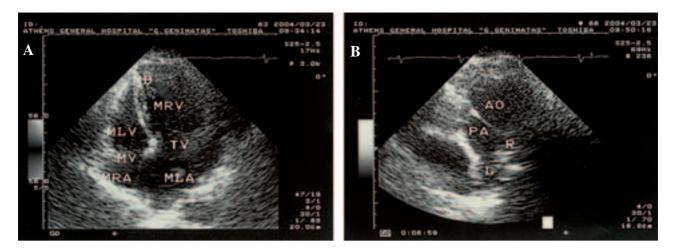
Transthoracic echocardiography. A: Apical four-chamber view. MB – moderator band; MLA – morphological left atrium; MRA – morphological right atrium; MLV – morphological left ventricle; MRV – morphological right ventricle; MV – mitral valve; TV – tricuspid valve. B: Modified left parasternal short axis view. The aorta arises in front of the pulmonary trunk, which is identified by its bifurcation.
